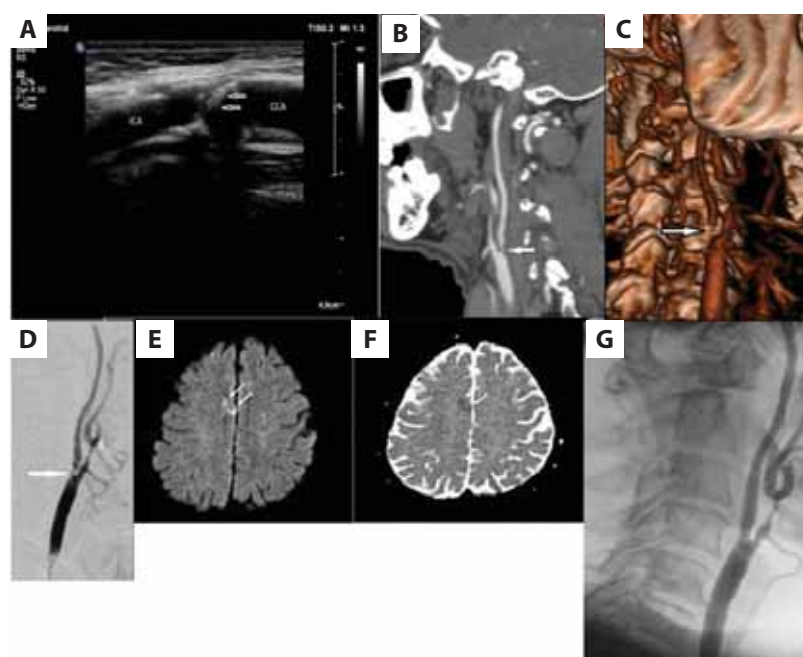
Noncalcified plaque-causing severe stenosis in the internal carotid artery (arrow). B-mode sonography (A), computed tomography angiography (B) 3D computed tomography angiography (C), and digital subtraction angiography (D). Postinterventional cerebral diffusion-weighted magnetic resonance imaging (E) shows the anterior cerebral artery territory high-signal intensity lesion (arrow). On ADC map (F), the lesion shows low-signal intensity (arrow) indicating its acute nature. Digital subtraction angiography after stenting (G)
